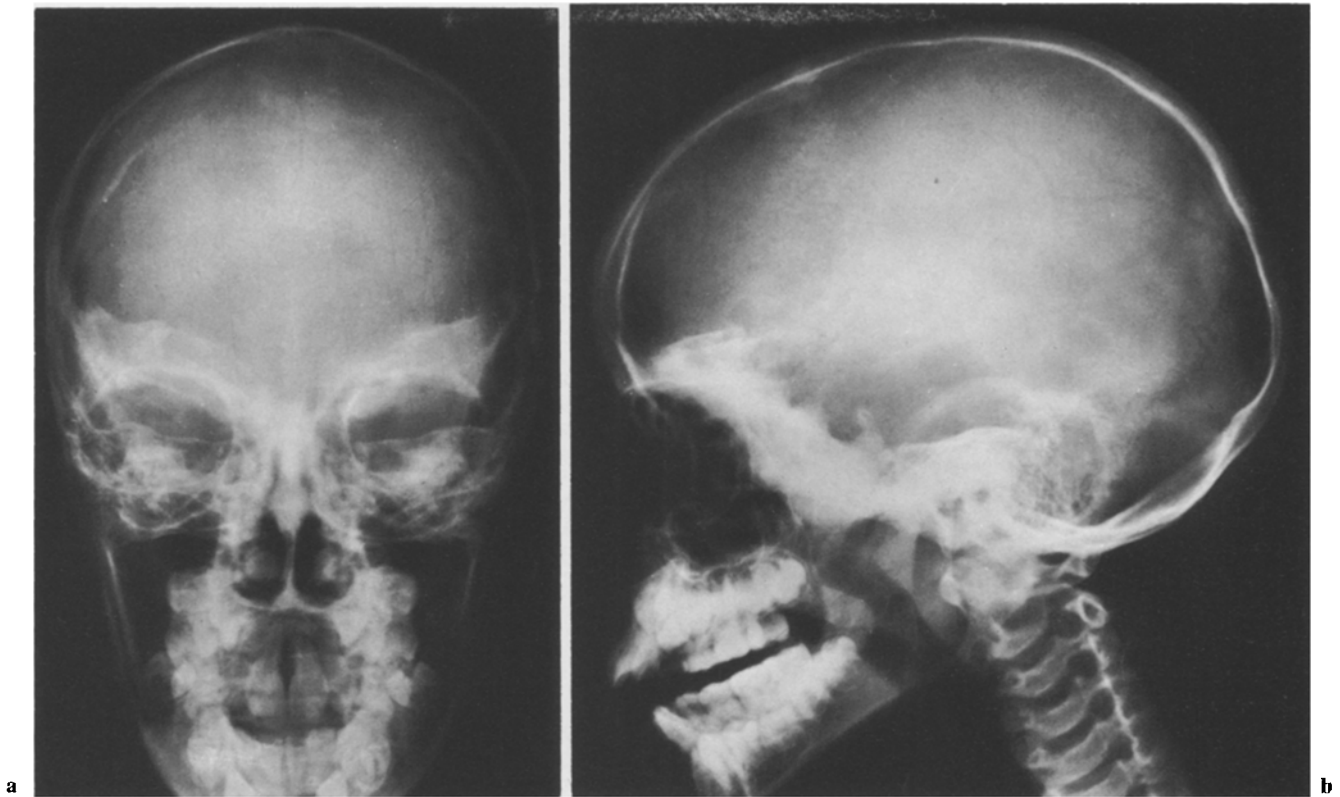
a PA roentgenogram of the skull demonstrates sclerosis of the inferior aspect of the frontal bone and sphenoid. b Lateral roentgenogram of the skull demonstrates marked sclerosis of the base which extends from the anterior floor to the clivus
